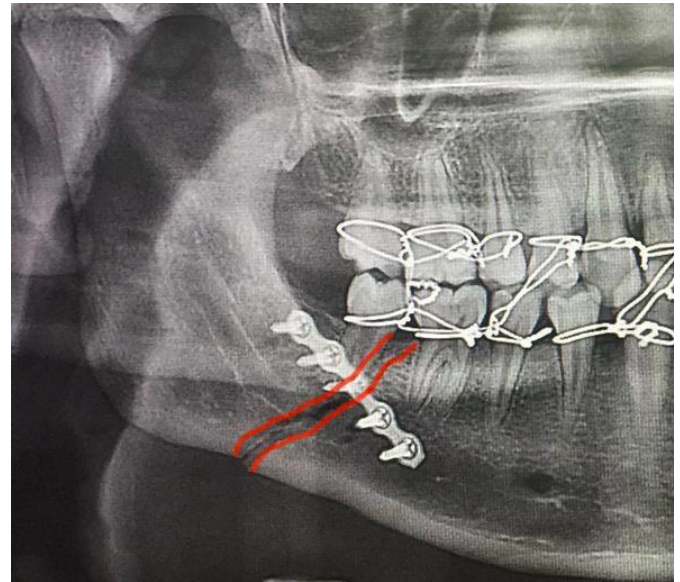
Panoramic Radiograph (Orthopantomogram) Showing Inadequate Fracture Reduction (>3 mm) Used in the Intraoral Technique
